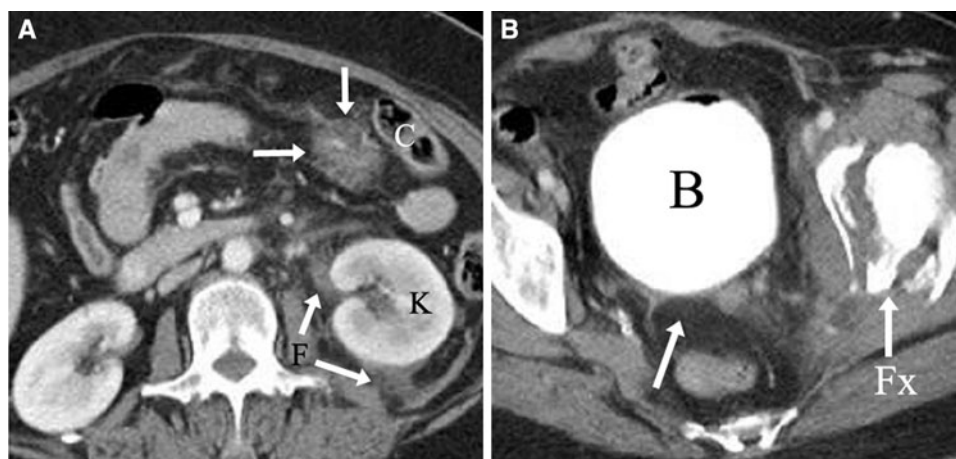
A 61-year-old male status post-blunt abdominal trauma. A Axial contrast-enhanced CT of the abdomen demonstrated a hematoma in the mesentery (*arrows*) near the distal transverse colon (*C*). Left kidney (*K*) with a small amount of perinephric fluid (*arrows*) was noted. B Axial
